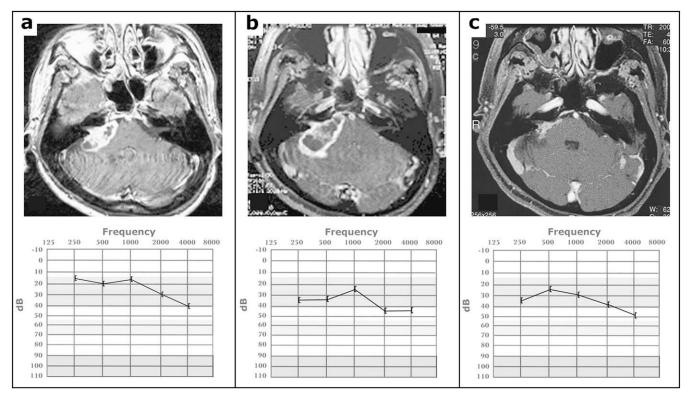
Serial magnetic resonance imaging scans (Upper) with associated audiograms obtained at same time (Lower) in patient treated with fractionated stereotactic radiotherapy to 46.8 Gy. (a) Pretreatment T_1 -weighted gadolinium-enhanced axial image featuring right acoustic neuroma. Audiogram reflects pure tone average of 22 and speech discrimination score of 95%, representing Gardner-Robertson level 1 pretreatment serviceable hearing. (b) Post-treatment T_1 -weighted gadolinium-enhanced axial image at 6 months featuring some enlargement and extensive central necrosis of tumor. Audiogram at 6 months after treatment reflects some audiometric decay with pure tone average of 35 and speech discrimination score of 100%, representing a decrease to Gardner-Robertson level 2 serviceable hearing. (c) Post-treatment T_1 -weighted gadolinium-enhanced axial image at 42 months featuring marked diminution in tumor size. Audiogram at 42 months after treatment reflects stable audiogram with pure tone average of 30 and speech discrimination score of 92%, back to lowest range of Gardner-Robertson level 1 serviceable hearing.
